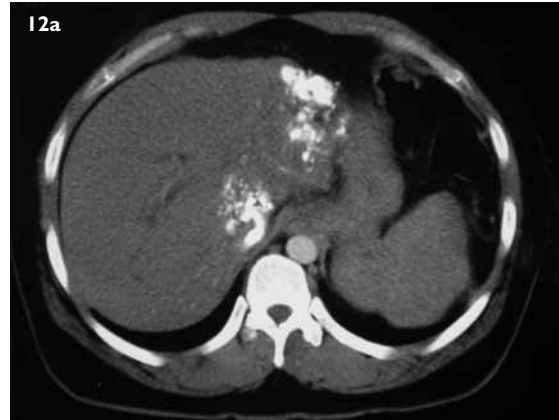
(a) CT image shows fine calcifications in a young man with previous hepatic involvement. The type of calcifications is finer (in contrast to the patient in Figs. 9 & 10). (b) CT image of an elderly man who presented with weight loss, fever, anorexia and abdominal pain shows hepatic calcifications (localised form) in segments 4 and 5. This patient was diagnosed with active TB of the ascending colon and was managed with anti-TB treatment, but his disease was complicated by multiple intra-abdominal sepsis with resultant portal vein thrombosis and gastric variceal bleeding. The patient eventually died of sepsis and variceal bleeding.
